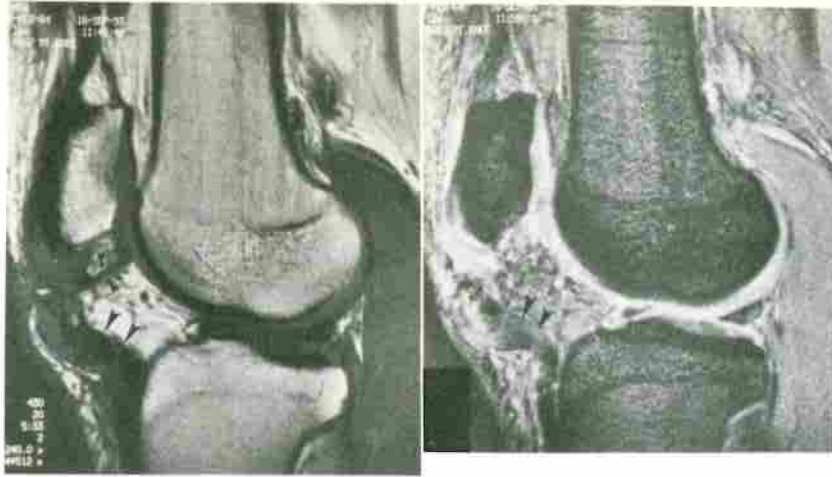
Acute patellar tendon rupture. The proximal patellar tendon ruptured spontaneously during a football game. A, Sagittal T1-weighted (TR/TE, 430/20) and (B) gradient-echo (TR/TE, 442/18; angle, 30 degrees) images show complete disruption of the tendon fibers (arrowheads) with retraction of the tendon. There is a mass of edema and hemorrhage at the site of rupture inferior to the patella. There is also traumatic disruption of the infrapatellar fat pad, best demonstrated on the T1-weighted image (small arrows). Also note a small bone fragment avulsed from the inferior pole of the patella (open arrow).
